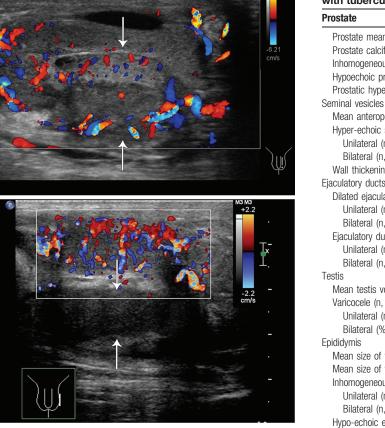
VD tuberculosis ultrasound findings (category 3, space-occupying lesions adjacent to vas deferens). (A) A male 56-year-old genital tuberculosis patient before antituberculosis treatment. The beginning of VD (the white arrow) was obviously enlarged as a spherical mass. Inside the mass, the echogenecity was heterogeneous. (B). In the same patient of Figure 4A, after treatments, the beginning of VD (indicated by the white arrow) was shrinked as rod-shaped mass and the echo was homogenous. VD = vas deferens.
